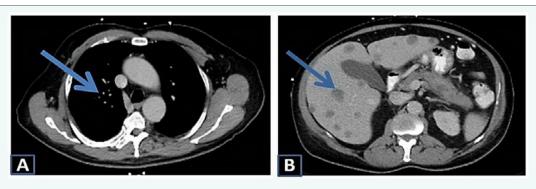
CT scan of the chest and abdomen showing multiple pulmonary (A) and liver (B) metastases (blue arrows).
